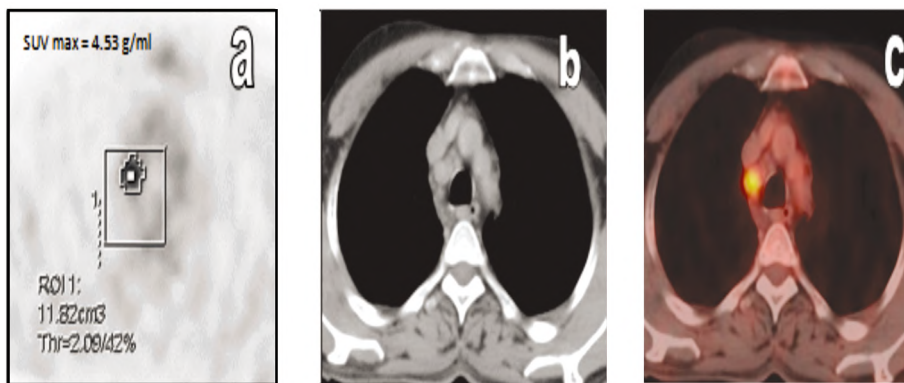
Axial PET-CT images in 13 years old male: Axial PET (A), CT (B) and fused PET-CT (C) Images demonstrating metabolically active (FDG avid) right upper paratracheal (retrocaval) lymph node SUV = 4.53 g/ml.
